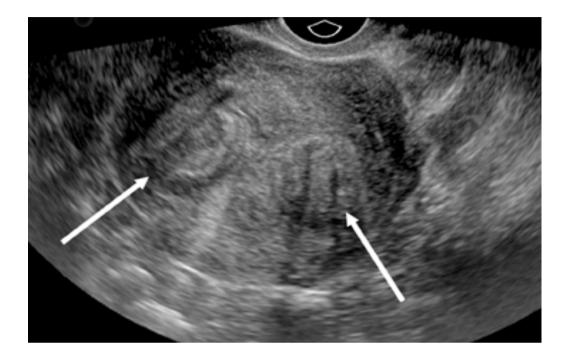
Ultrasound image of a uterus enlarged by multiple myomas
